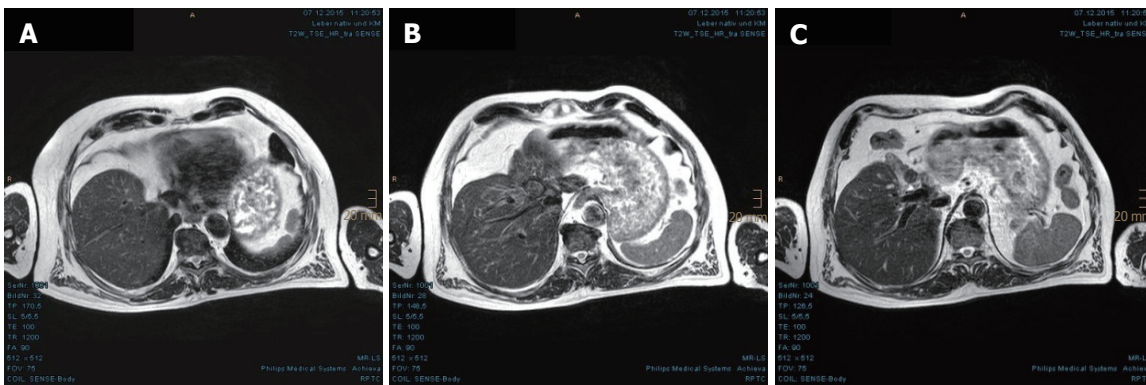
Continuous tumor shrinkage evidenced in the magnetic resonance imaging scan at 21 mo after proton beam therapy. A-C: Further size reductions of the residual tumor nodules in the axial plane are shown.
